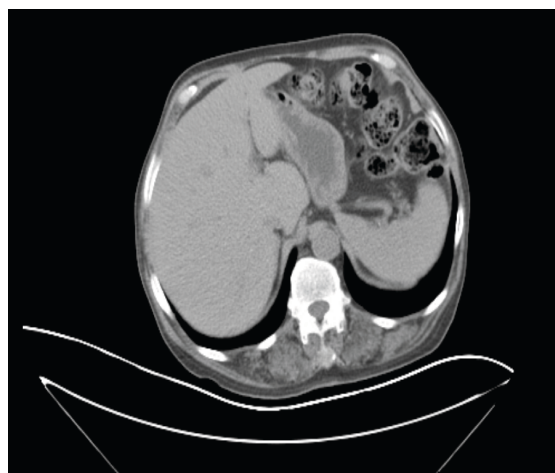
CT after chemoradiotherapy.
